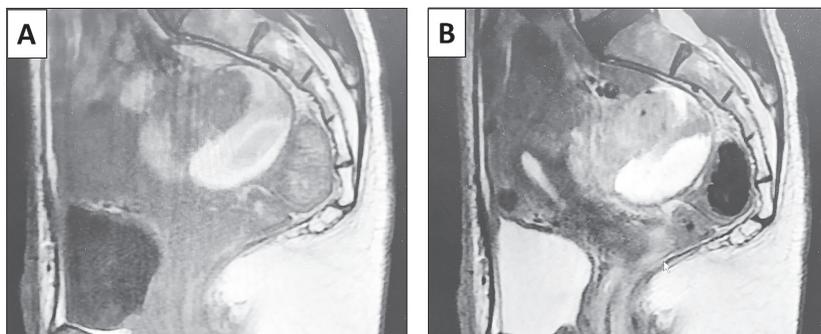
MRI findings show diffuse low to intermediate signal intensity, and partially high signal intensity on T1 and T2-weighted images (A: T1-weighted, B: T2-weighted).
